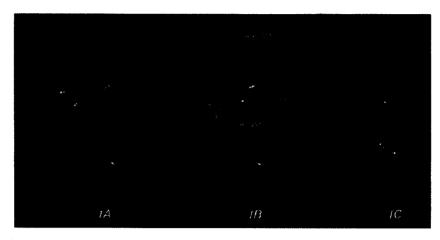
Molecular modeling results for the human α-thrombin active site. 1A and 1B: The two energy minimized positions for 4-methyl imidazolium ion (orange) in the S1 pocket. The D-Phe-Pro-NH scaffold (green) from the starting X-ray structure² was used. 1C: The energy minimized complex for the three carbon tethered analog (green). In each figure, possible hydrogen bonds are shown as thin dashed lines.
